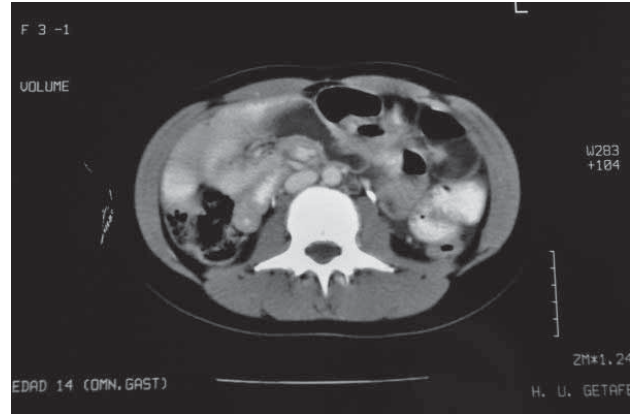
Abdominal computed tomography image of the first episode of eosinophilic gastroenteritis showing thickening in the small bowel wall and ascites.
